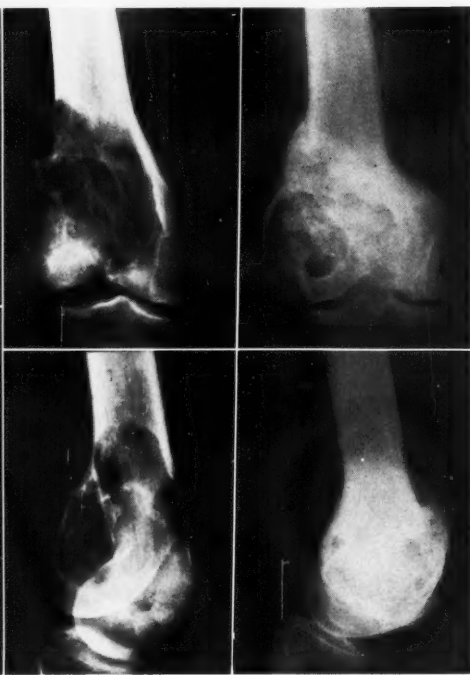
Case 33: Giant-cell tumor of right lower femur with two consecutive pathologic fractures before and five years after roentgen therapy. No biopsy.
